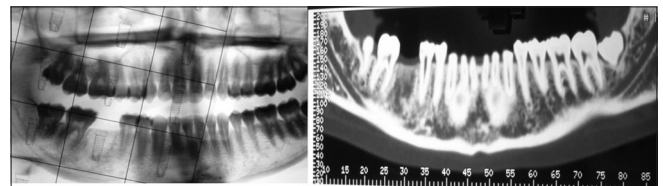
Orthopantomography with radiographic template and Dentascan with measurements
